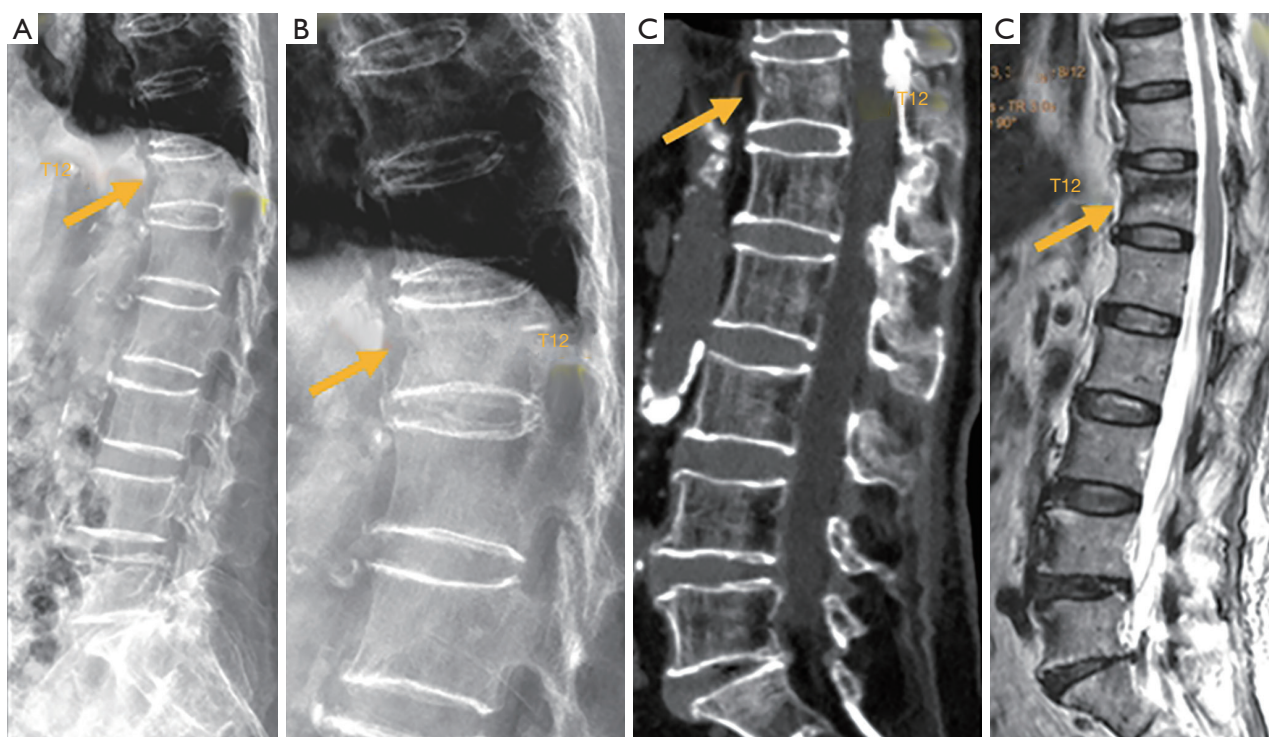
Subtle osteoporotic fracture after low energy trauma (arrow). (A) Radiograph; (B) radiograph magnified view for T12; (C) sagittally reconstructed CT; (D) T1 weighted MRI. On radiograph T12 vertebral anterior cortex buckling is noted. There is no apparent height loss of the vertebral body. CT confirms T12 fracture and vertebral anterior cortex break. MRI also confirms T12 fracture. CT, computed tomography; MRI, magnetic resonance imaging.
